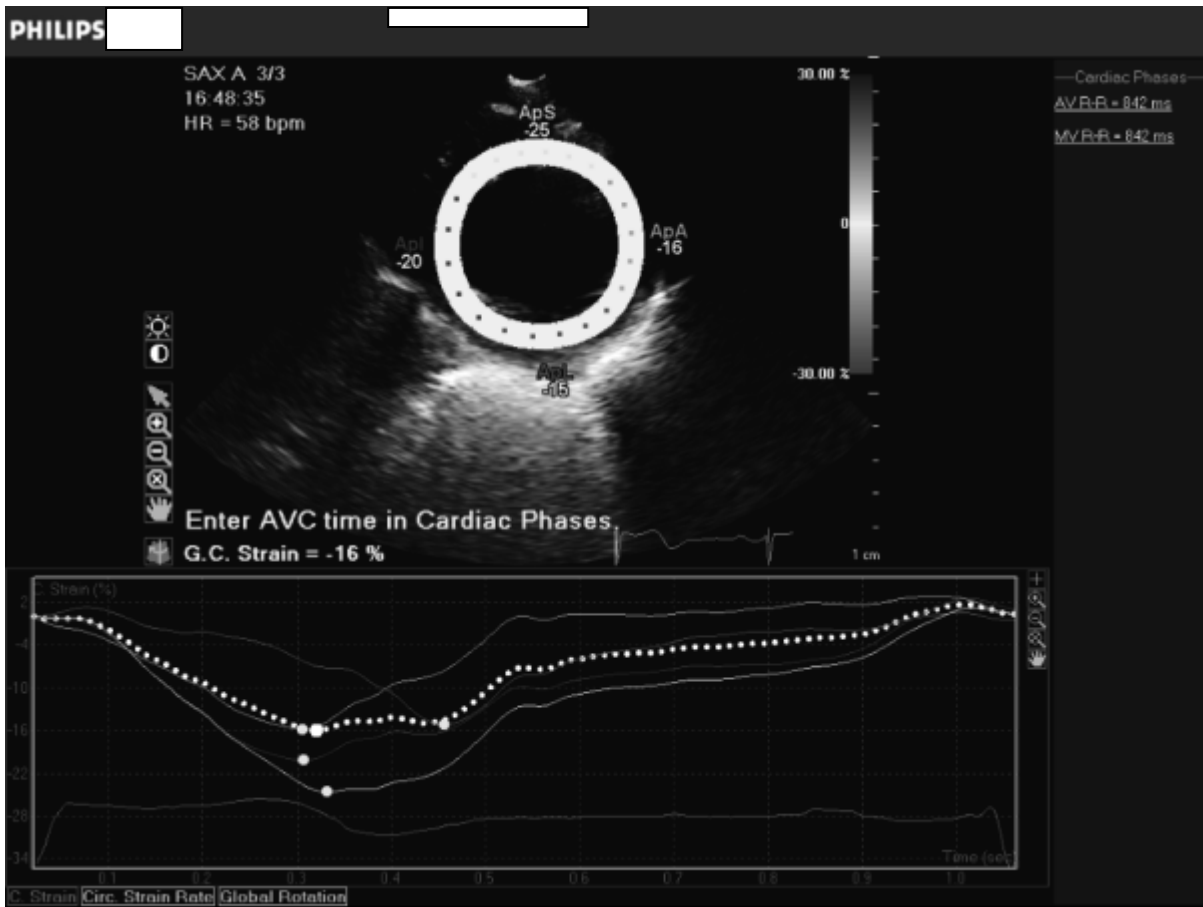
Parasternal short axis view at apical level for global circumferential strain
